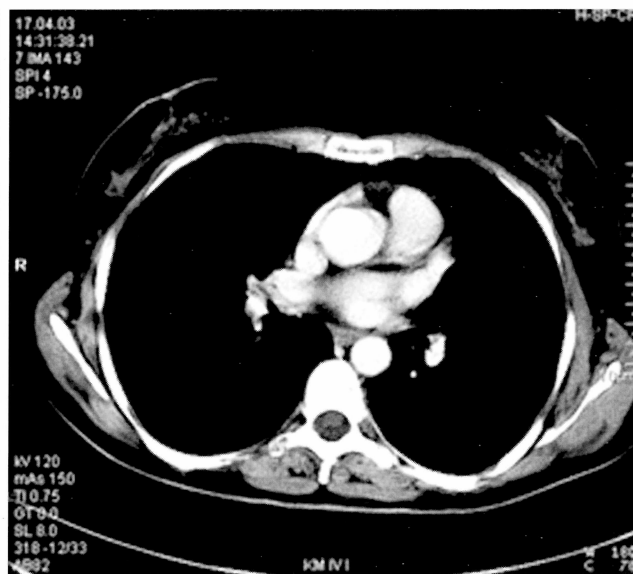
Pulmonary metastasis can clearly be seen in the lateral periphery of the lungs on the right side (arrow). CT scan of the thorax before systemic treatment (contrast medium enhanced).
